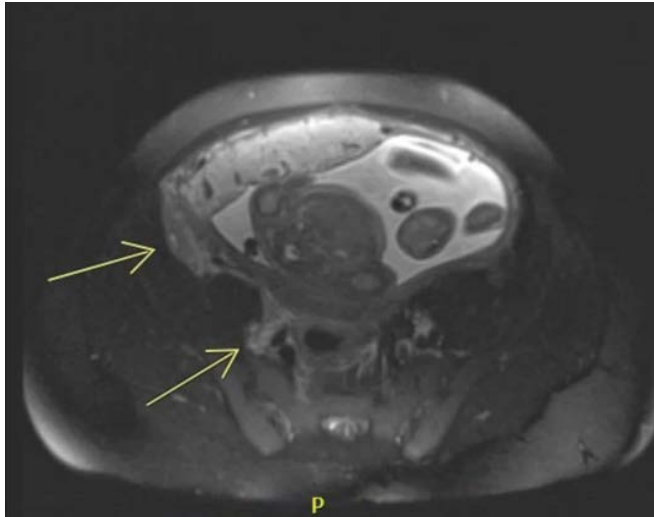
MRI of the pelvis showing evidence of mild fat stranding with a small amount of free fluid in the pelvis.
